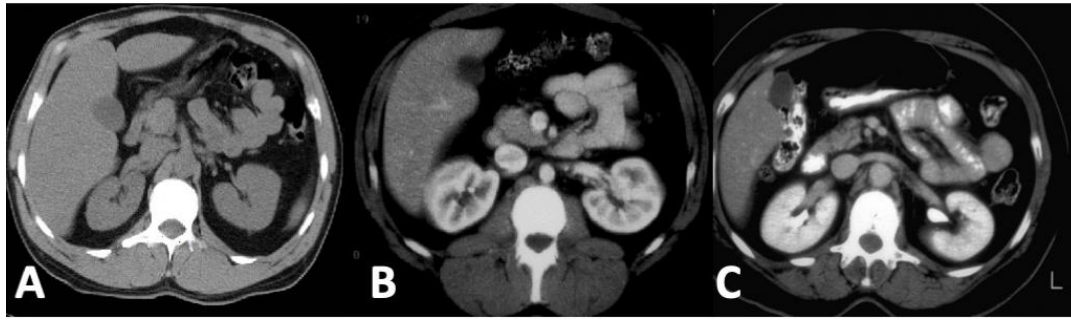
Tri-phasic CT Urography with non-contrasted (A), contrasted (B), and delayed (C) phases. From: <https://university.auanet.org>
